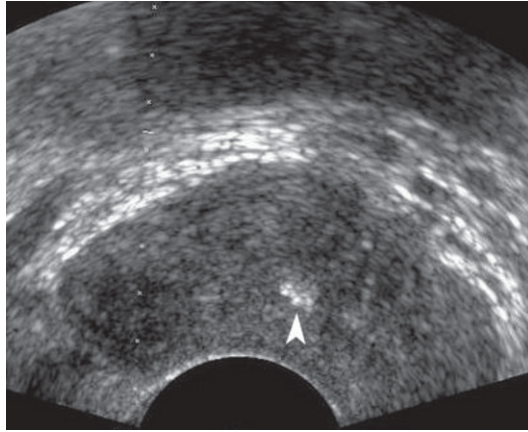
Ultrasonography. Prostate. Transrectal approach. Calcifications (*arrow-head*) are evident in the central portion of the gland
